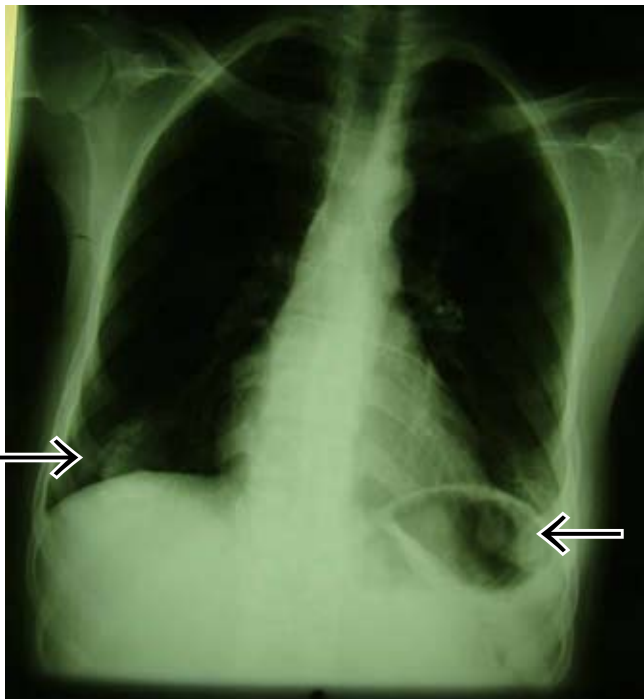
Frontal chest X-ray showing bilateral cutaneous neurofibromas of the areola projecting over the lung fields.
